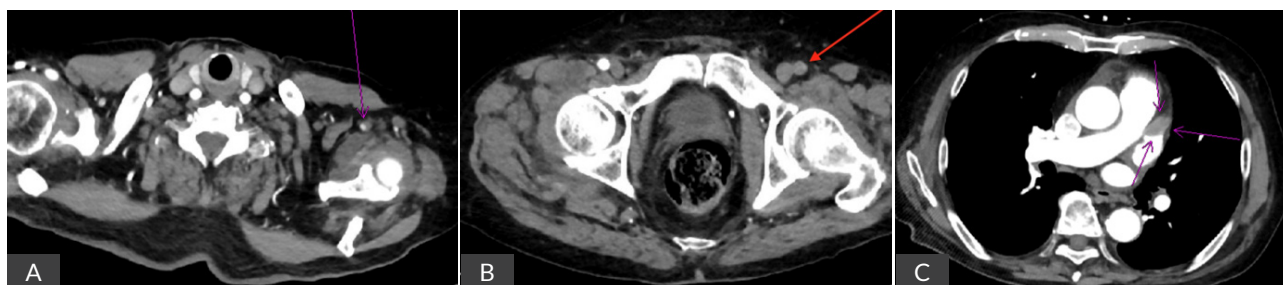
Contrast-enhanced computed tomography imaging findings demonstrating vascular abnormalities: A) Partial visualization of severe, near-occlusive stenosis in the left axillary artery (purple arrow); B) Complete occlusion of the left common femoral artery (red arrow); C) Thrombus in the left atrial appendage (purple arrows).
